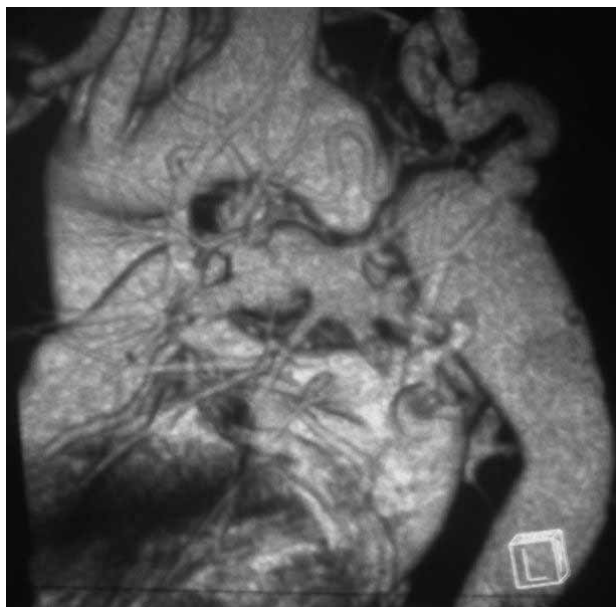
Multi-slice computed tomography (MSCT) shows a total interruption of the aorta. Collateral vessel inflowing distal of the interruption can be seen.
